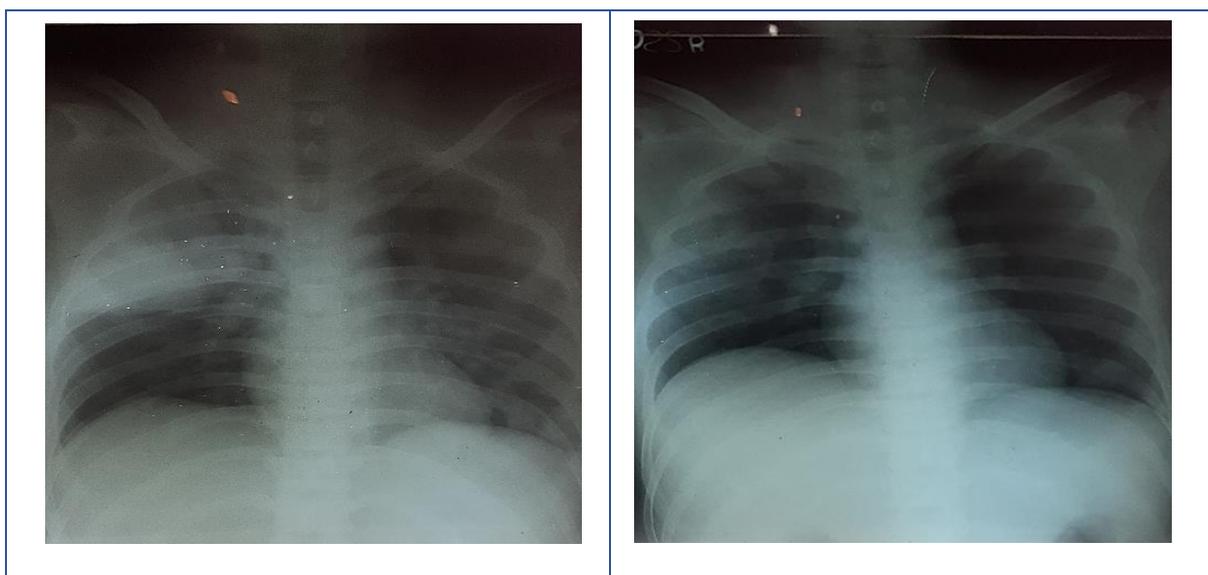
Chest Xray – right upper lobe consolidation (left), complete resolution of consolidation after two weeks of treatment (right).
